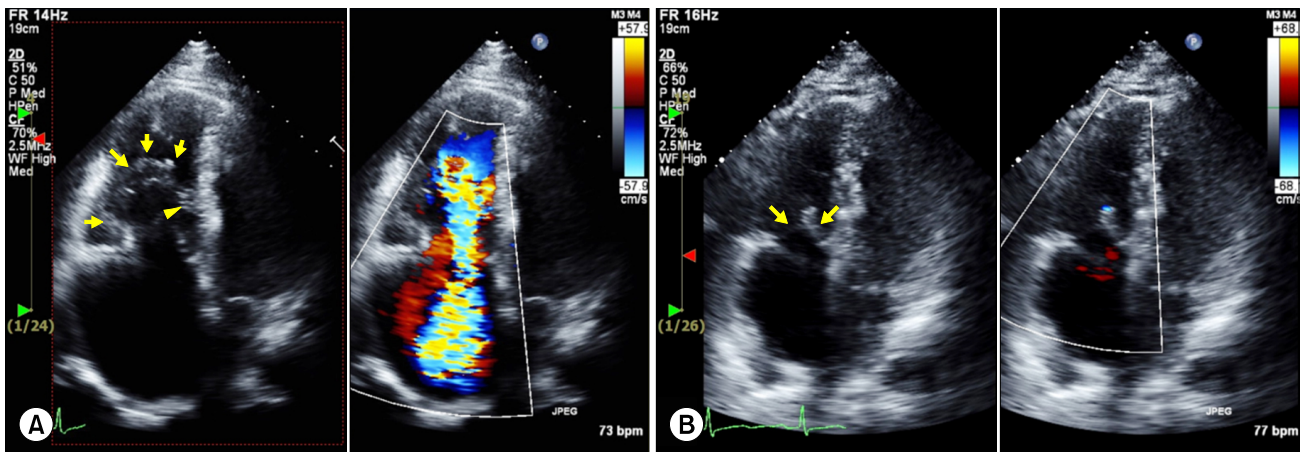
Echocardiogram of case 1. (A) A preoperative apical four-chamber echocardiogram. The septal and posterior leaflets are apically displaced and adhere to the underlying myocardium (arrowhead). The leading edge of the anterior leaflet is mobile, although the basal portion is tethered to the ventricular wall (arrows). Color Doppler scanning reveals severe tricuspid regurgitation from the apically displaced leaflet coaptation site. (B) Postoperative echocardiography 15 months after the cone repair reveals a competent tricuspid valve at the true annulus level (arrows) without tricuspid stenosis.
